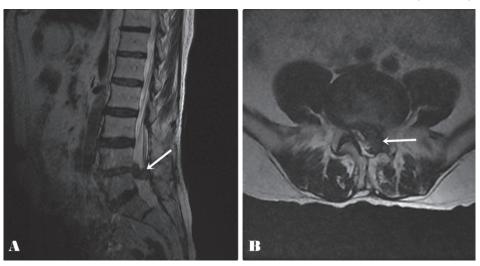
Inferiorly migrated disc in MRI scans MRI: Magnetic resonance imaging
